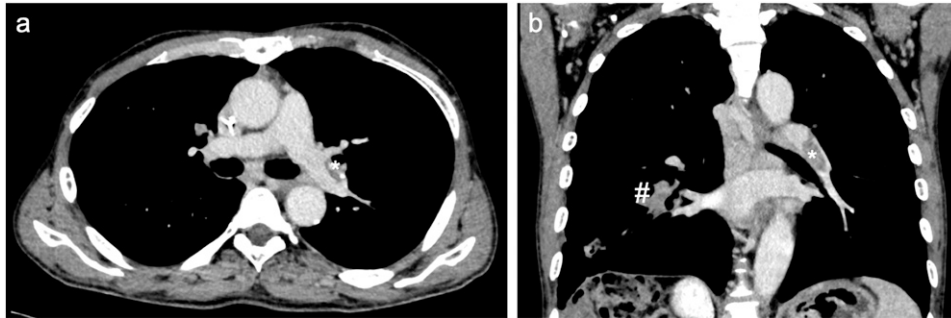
(a), (b) Follow-up Computed tomography angiography (3 months after chemotherapy change) revealed stable wall-adherent pulmonary artery emboli in the left main pulmonary artery with calcification (*) and regressive pulmonary metastasis (#).
